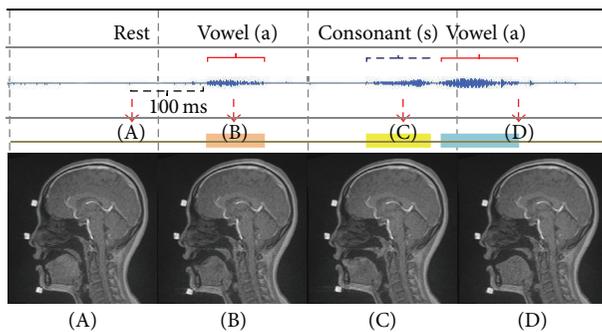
Representative sound data combined with movie MRI of a Thai subject. A–D are the corresponding sound signals and MR images.
